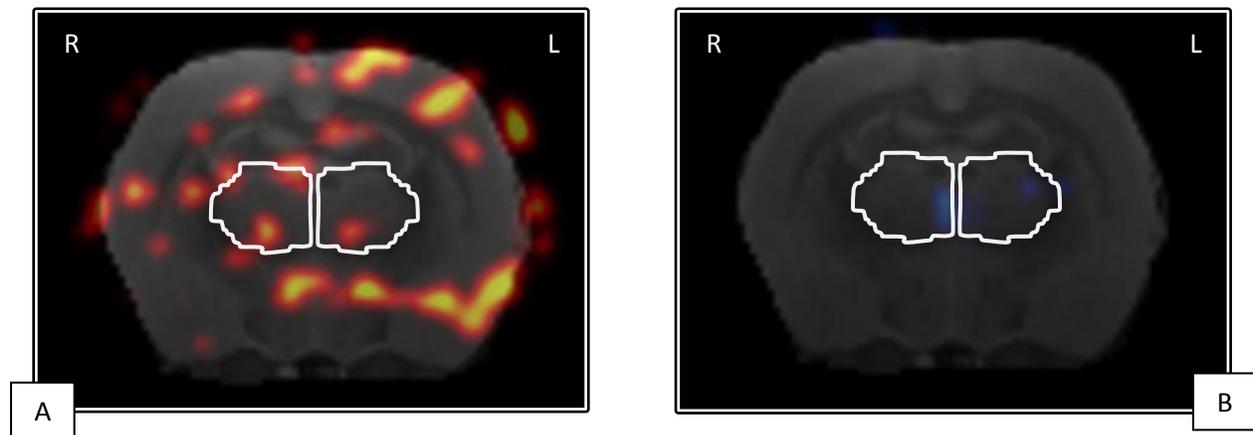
PET-FDG image of the thalamus.
